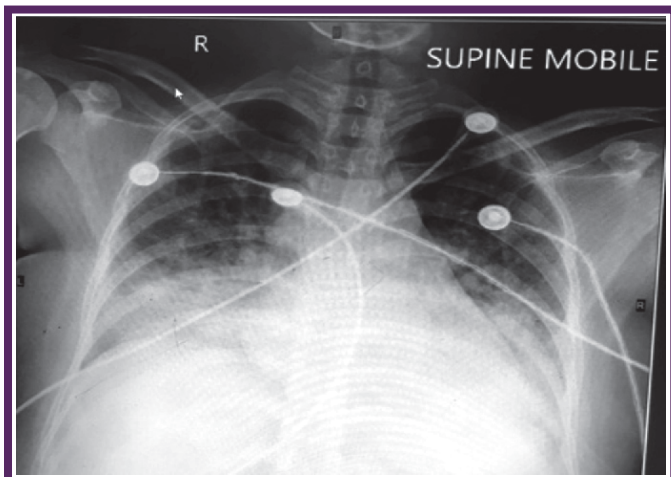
Chest radiograph showing non homogenous opacity in both right and left lung lower zone
